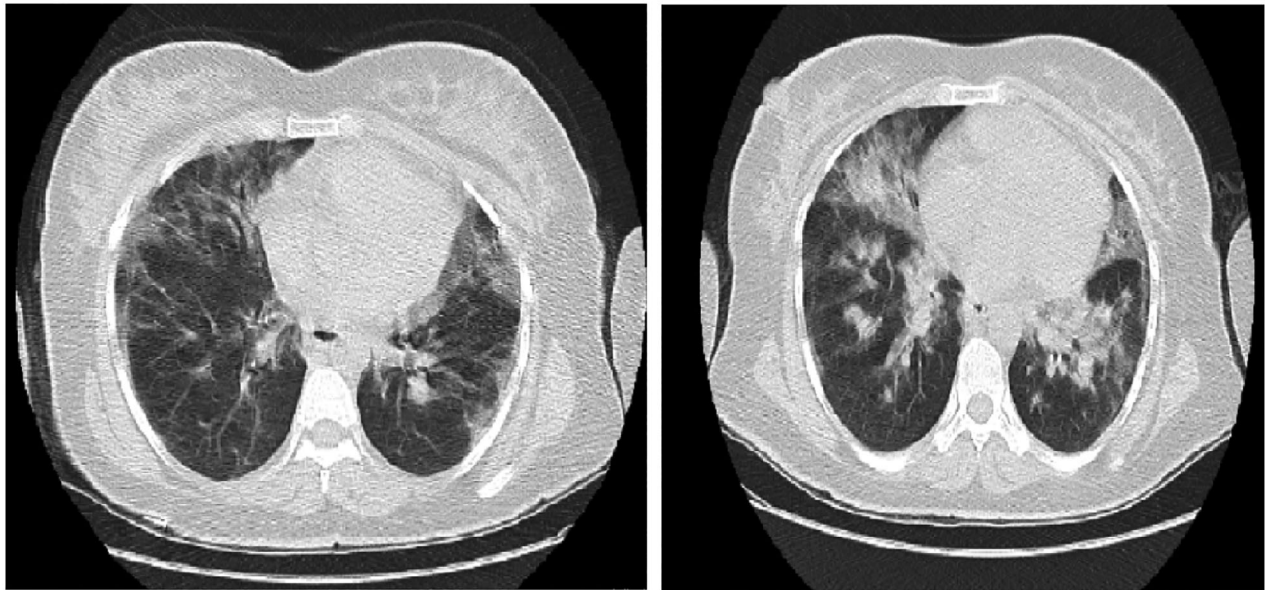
Case 1's CT images show increasing opacities in the lung at the postpartum period (left; antepartum, right; postpartum)
